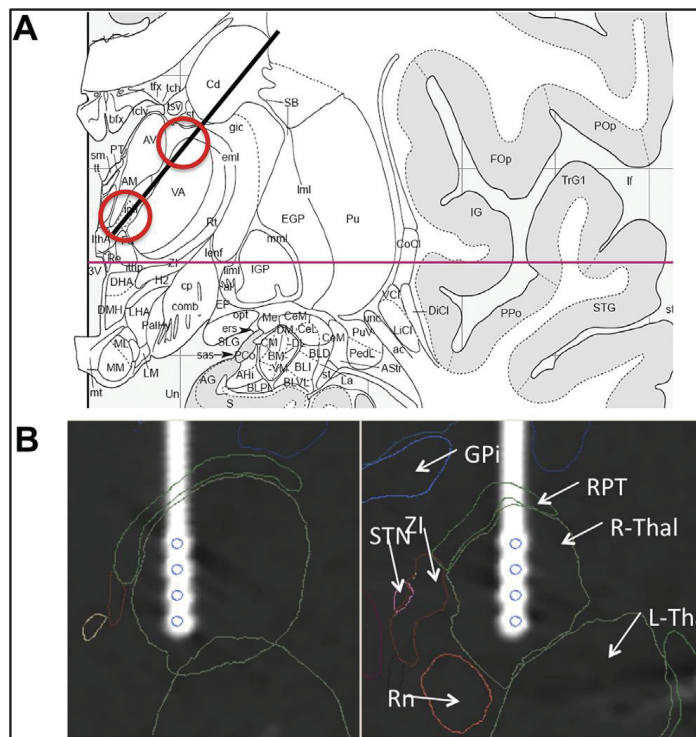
Anatomische Lokalisation der Elektroden bei Ableitung aus dem zentralen Thalamus bei *chronic disorder of consciousness* (DOC). A: Geplante Trajektorie (schwarze Linie) projiziert auf einen anatomischen Atlas (Mai et al., 2004), Sektion 30, koronar, 10,7 mm hinter der anterioren Kommissur (rote Linie verbindet anteriore und posteriore Kommissur). Rote Kreise zeigen die angestrebten Zielpunkte entlang der Elektrode. iml= interne medulläre Lamina des Thalamus, Rt= retikulärer Thalamus, VA= venteroanteriorer Thalamus, AV=anteroventraler Thalamus, AM= anteromedialer Thalamus, Fa= Nucleus fasciculosus, IthA= Adhäsio interthalamica. B: Finale Elektrode im zentralen Thalamus im 3D-Atlas (Yelnik et al., 2007). Zwei orthogonale Schichten entlang der Achse der rechten Elektrode nach Co-Registrierung des Atlas mit postoperativem CT. Die vier Kontakte der Elektrode (blaue Kreise) liegen im rechten Thalamus (R-Thal). ZI= Zona incerta, RPT= retikulärer perithalamischer Nucleus, RN= Nuclues ruber; aus: Wojtecki, et al. 2014
